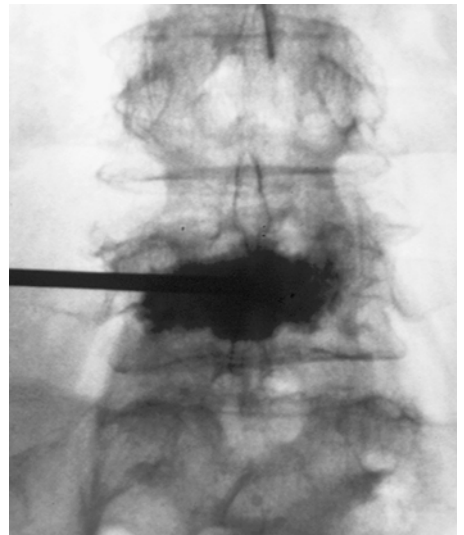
Lateral (A) and anteroposterior (B) radiographs following a bilateral transpedicular PV reveals 70% or greater filling (white arrow in A) with no evidence of leak. It is important to fill the anterior 2/3–3/4 of the vertebral body. In the anteroposterior view, cement should cross the midline to reinforce both halves of the vertebra (white arrows). (C) Anteroposterior radiograph of a unipedicular PV shows distribution of cement into both halves of the vertebra.
